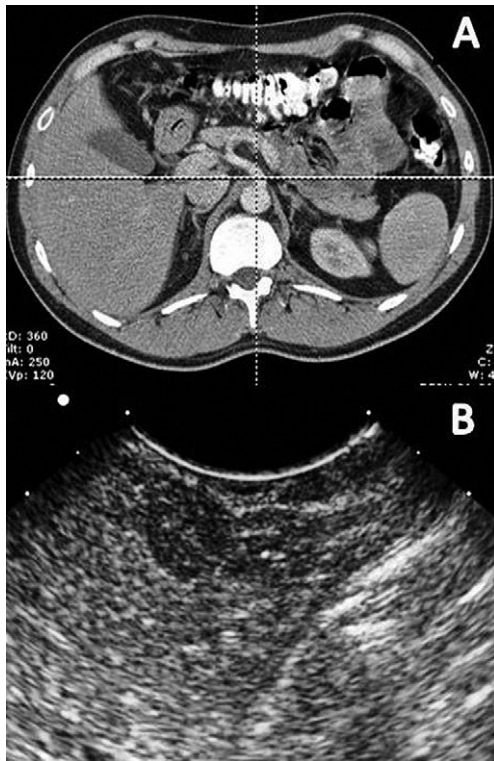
Negative CT finding in a 32-year old male with recurrent hypoglycemia episodes (A). A 5 mm lesion in the pancreatic body was detected at EUS (B).
